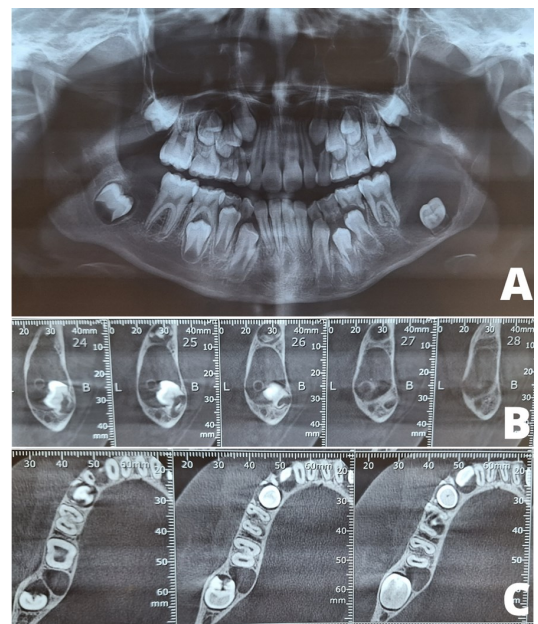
Control panoramic radiograph four months after treatment, new bone formation and new lesion are observed in the right mandibular body (A). Coronal sections of the lesion of the left mandibular body, in situ drainage with bone neoformation is observed (B). Axial sections of the right mandibular lesion, a close relationship with piece 4.7 (C) is observed.
